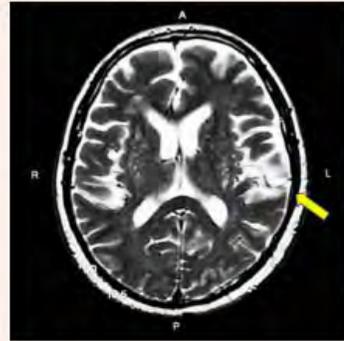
T2-weighted MR image showed old infarct of left temporoparietal lobe
